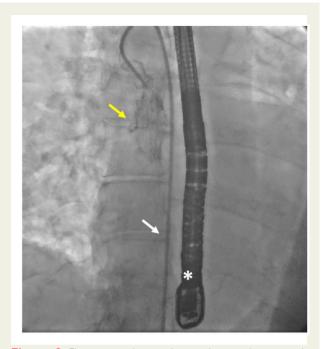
Fluoroscopy during edge-to-edge mitral repair with transoesophageal echocardiography guided (asterisk) indicating an abnormal position of the wire ascending from the femoral vein at the left side of the vertebrae (white arrow) and contrast flow jet from multipurpose A catheter-directed downward and to the left side indicating right-sided chamber (yellow arrow). TOE, transoesophageal echocardiography; MPA, multipurpose A.
